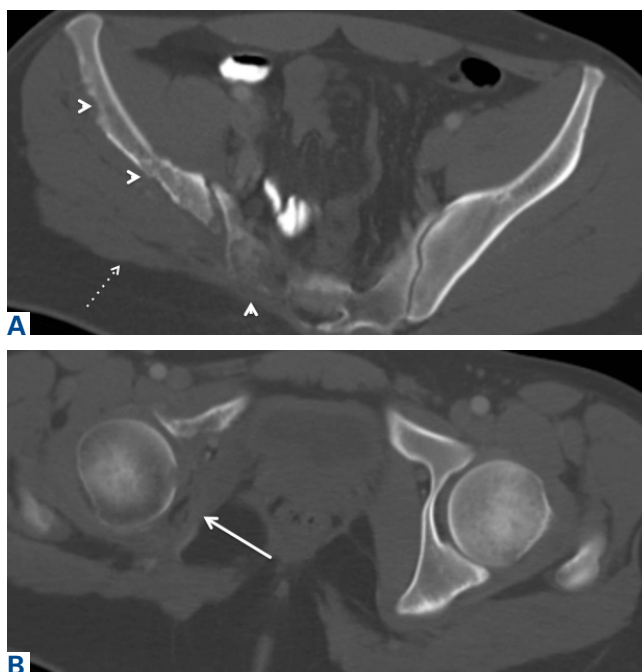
(A) Contrast-enhanced axial computed tomography (CT) shows extensive permeative osteolysis of the right sacrum and the right iliac bone (white arrowheads), which is destroyed posteriorly, and asymmetric atrophy of the right vs left gluteal muscles (white dashed arrow). (B) Axial CT more inferiorly shows obliteration of the right medial acetabular wall (white arrow).
